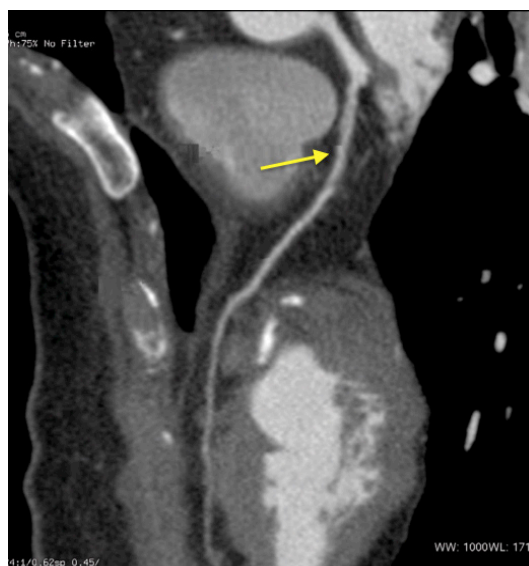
Multiplanar reformation of coronary computed tomographic angiography, detecting a severe parietal irregularity in the proximal third of the anterior descending coronary artery, which suggested the presence of a noncalcified plaque or dissection of the artery (arrow).
